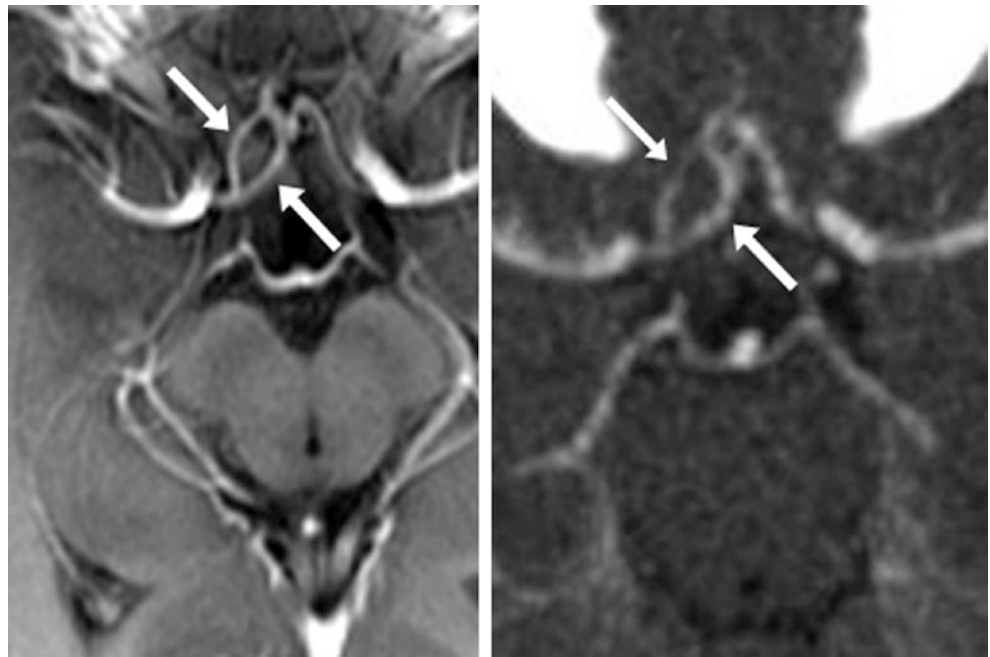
58-year-old with bilateral ACA A1 segment fenestrations (*arrows*), shown on T2WI MRI (*top left*), 3D VR CTA superior view (*right*), and a 20-mm axial MPR from the CTA (*bottom left*)
